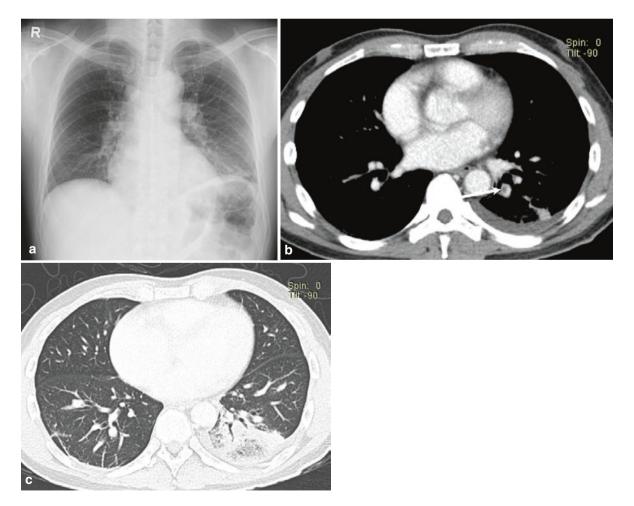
A 57-year-old man with acute PE. (a) Frontal radiograph shows the elevation of the left hemidiaphragm and peripheral linear band-like opacity (Fleischner line) with surrounding haziness in the left costophrenic angle.
